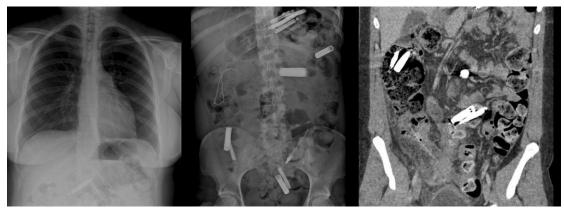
Chest X-ray showing two e-cigarettes, projected over distal oesophagus and stomach (left panel). Abdominal X-ray performed two months later demonstrating 13 foreign objects (central panel). Partially opaque hand spoon at CT scan perforating the caecum (right panel).
